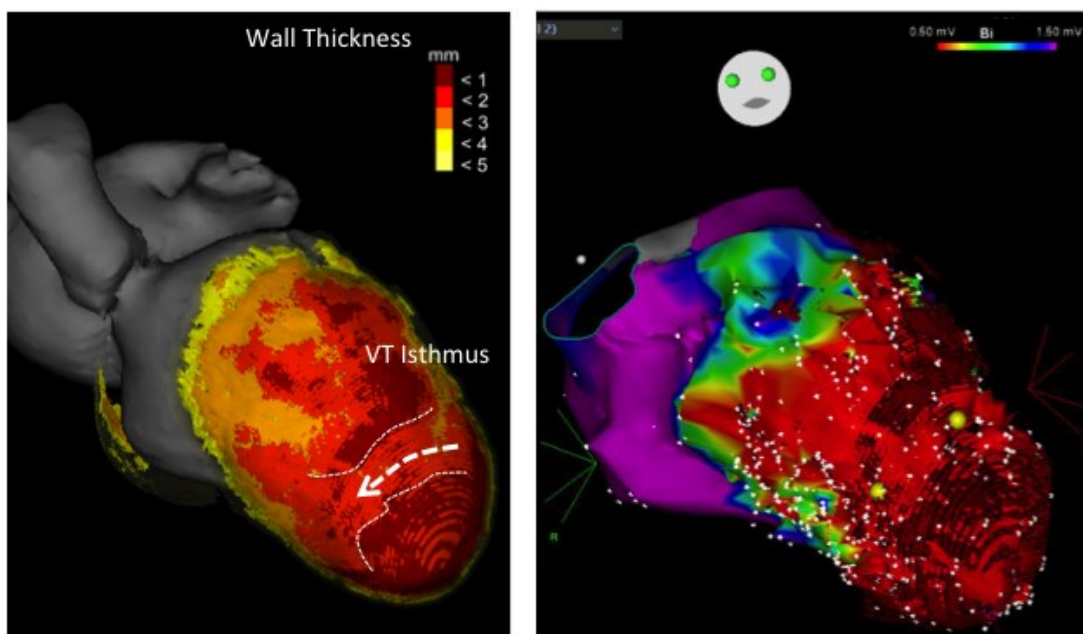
Left Panel: Wall thickness as determined by CT. Shown is the anteroseptal aspect of the left ventricle from a patient with a prior anterior wall myocardial infarction. The wall thickness is color coded. A VT isthmus is indicated in the anteroapical free wall. The isthmus is located between 2 distinct areas of thinning (<1 mm in wall thickness) between the apex and the mid anterior left ventricle (white lines and arrow).
